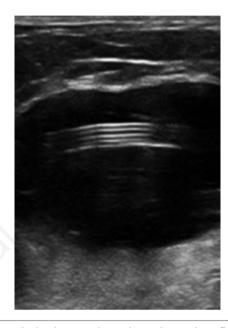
Bedside ultrasound revealing a hypoechoic fluid collection with a tubular foreign body.
